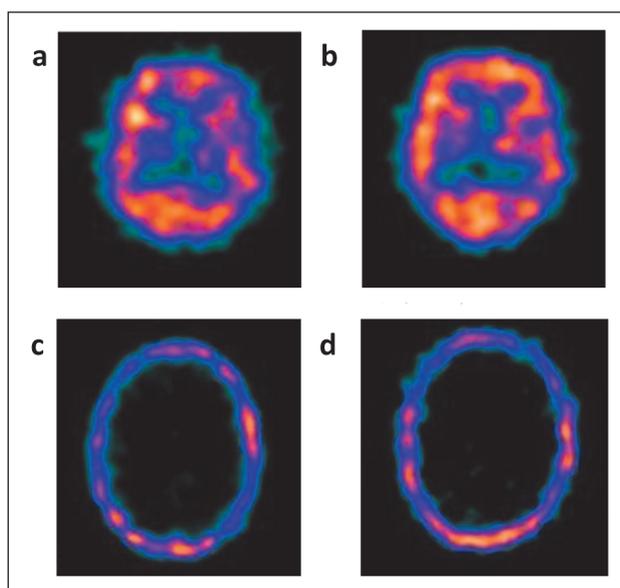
$^{99m}\text{TcHMPAO}$ SPECT transaxial slice (a) before and (b) after zolpidem, and $^{99m}\text{TcDTPA}$ SPECT transaxial slice (c) before and (d) after zolpidem.
